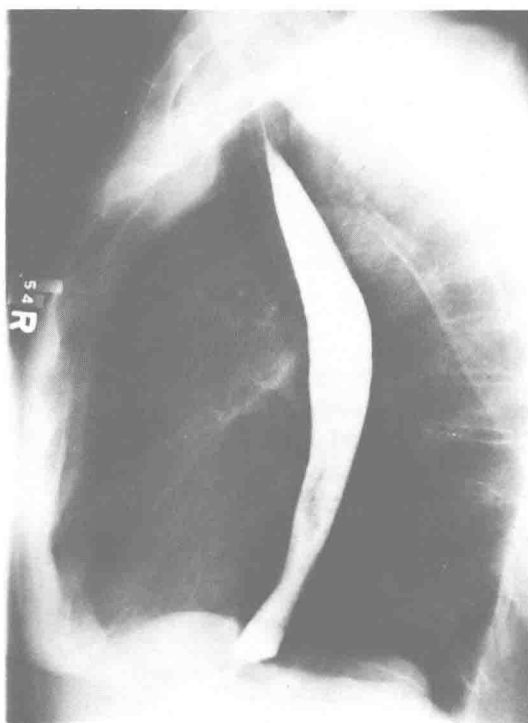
X-ray film of the entire barium-filled esophagus, showing the course of this organ through the mediastinum from hypopharynx to stomach. Note the three indentations produced by the aorta, left main-stem bronchus, and left atrium.
